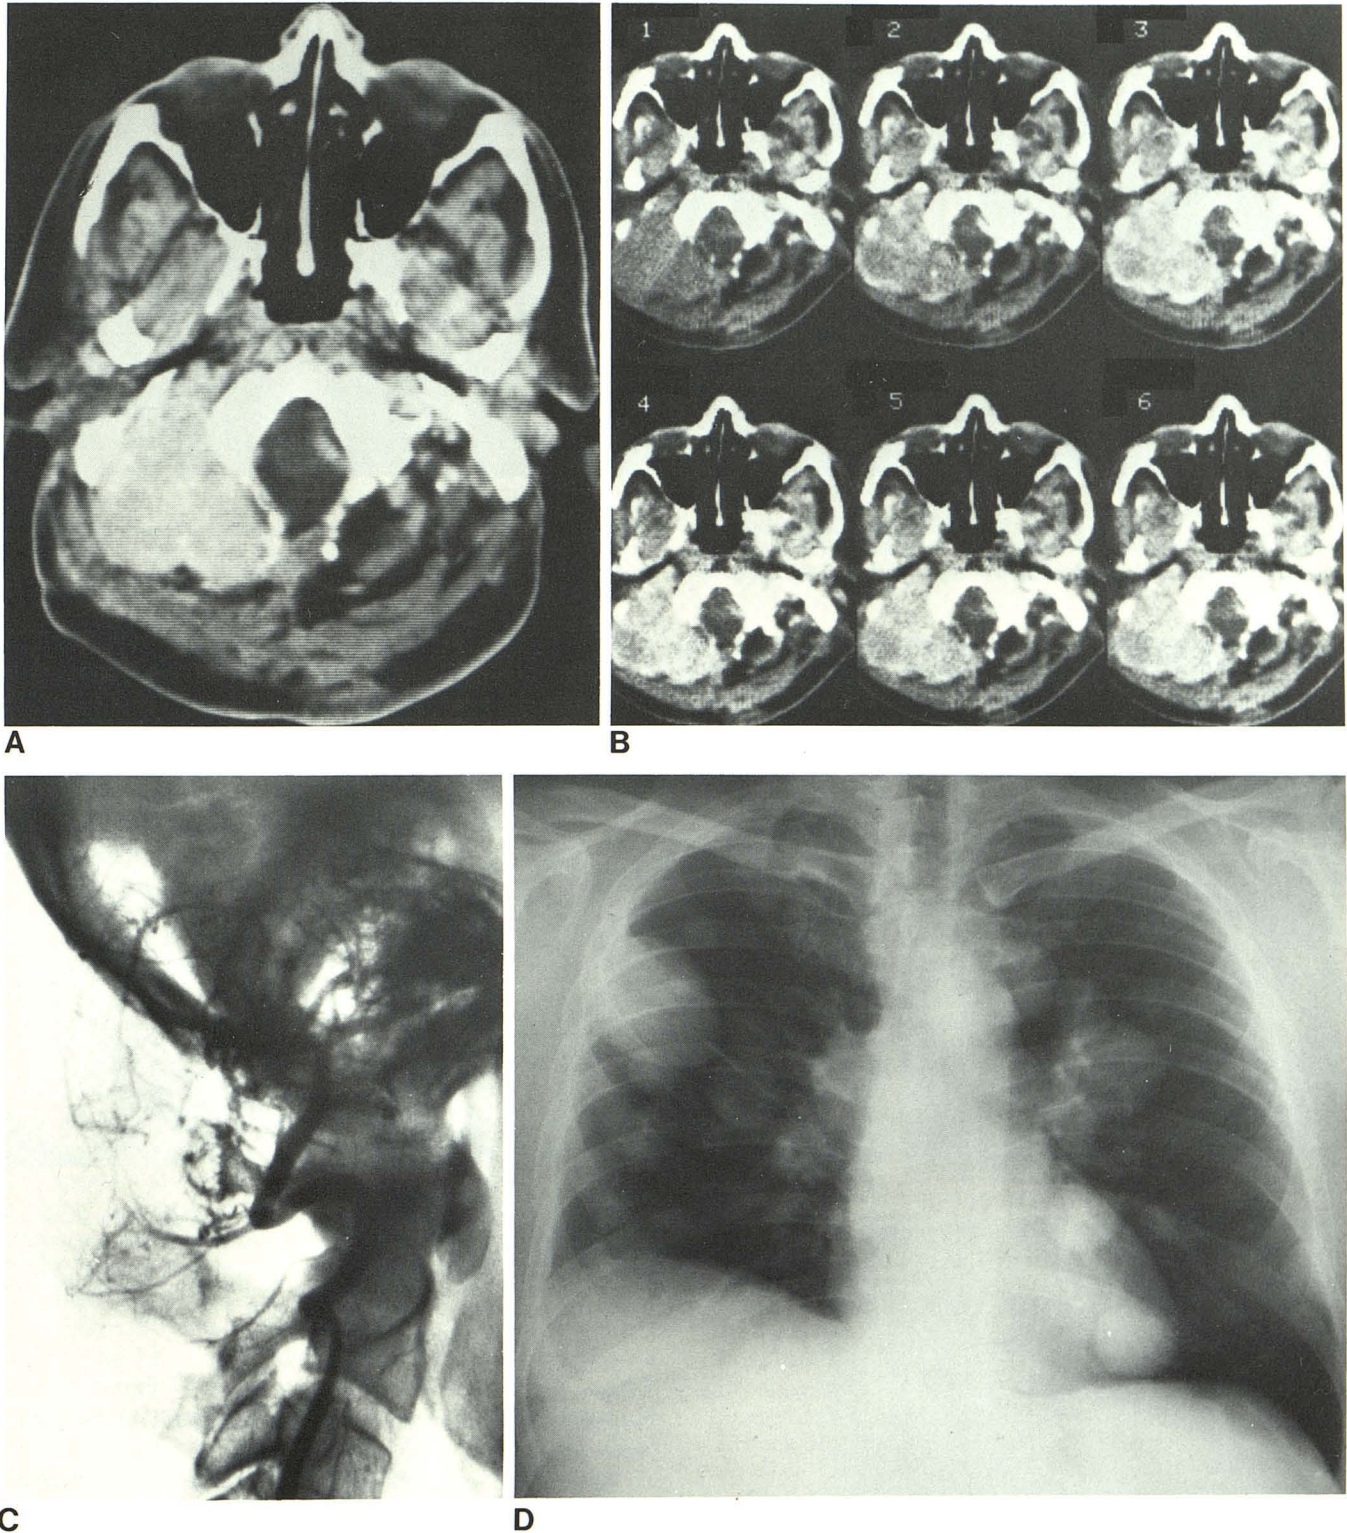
Case 2. Occipitocervical hemangiopericytoma. A, CT scan. Diffusely enhancing tumor, occipitocervical region. No calcification. B, Bolus contrast-enhanced rapid sequence CT. Serial scans of 4.8 sec duration, 1
